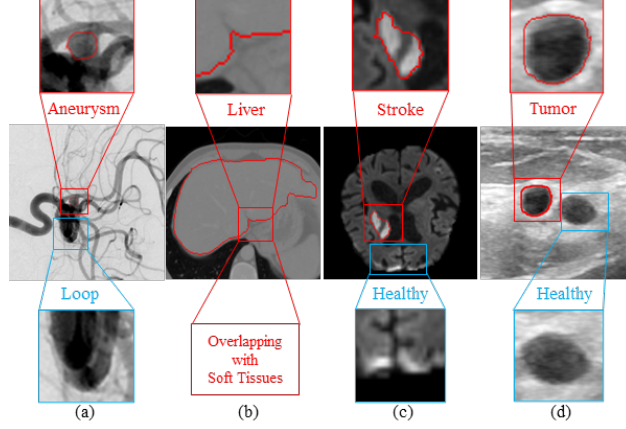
Challenges in medical image segmentation across different modalities: (a) DSA: a partially hidden aneurysm behind the cluttered arteries and loops having similar dye contrasts, (b) CTA: overlapping soft tissues with liver due to low tissue contrast, (c) MRI: irregular boundaries and identical contrast of stroke and healthy tissue, and (d) Ultrasound: similar tumor and healthy tissue structure in breast.
